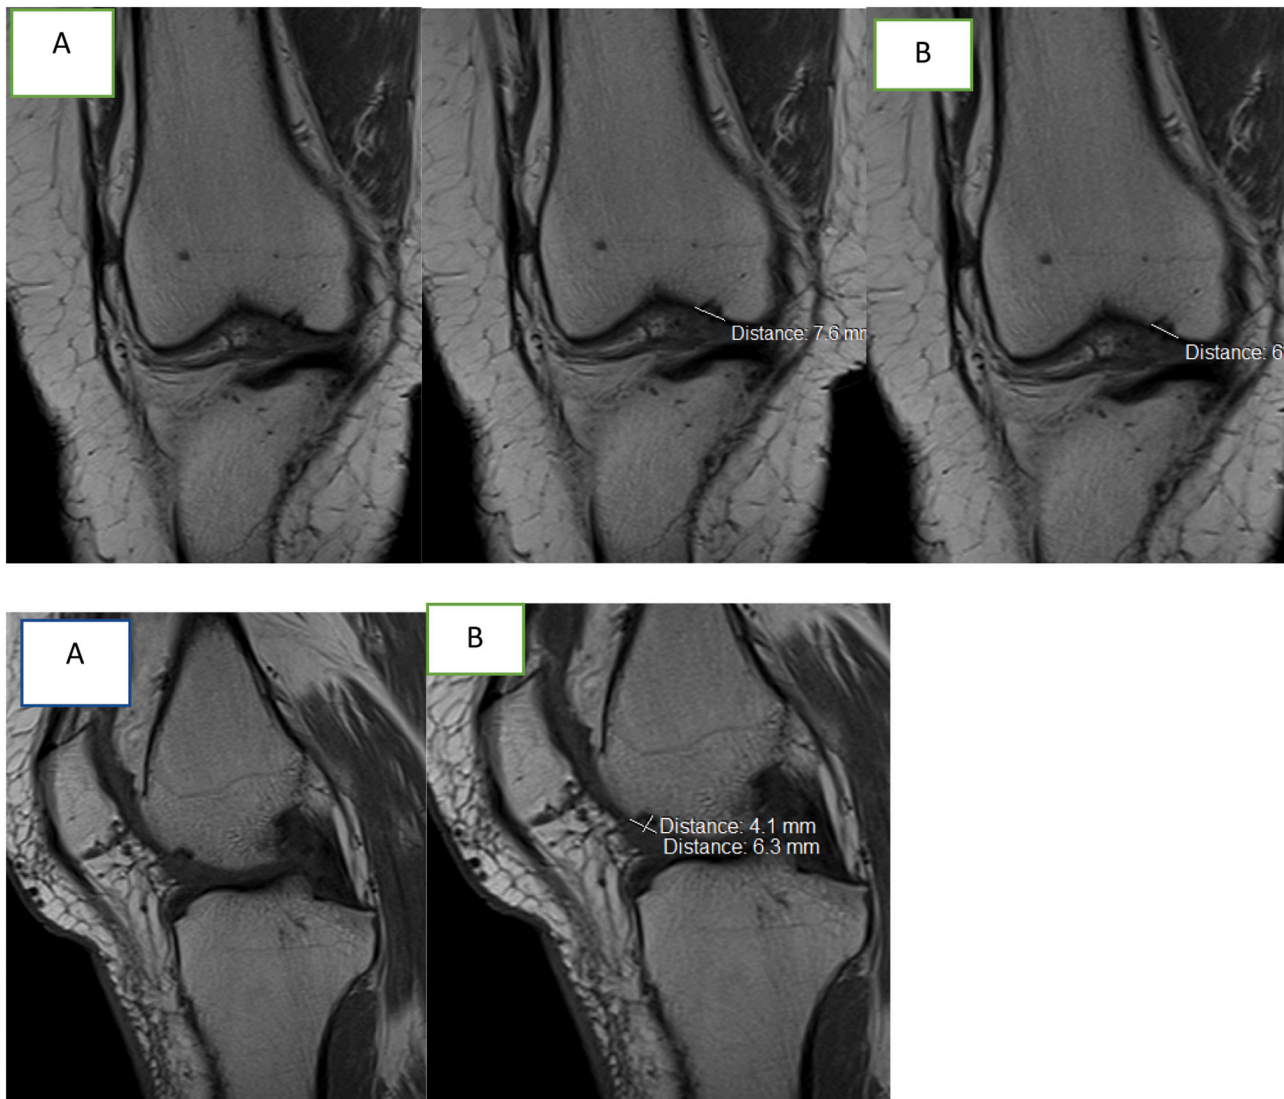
Patient 3. MRI pre-operative (A) and postoperative (B) showed improvement of Cartilage (preoperative 7,5 mm postoperative 6,0 mm) with AMADEUS score 65 (grade 2) preoperative and 65 (grade 2) postoperative.
